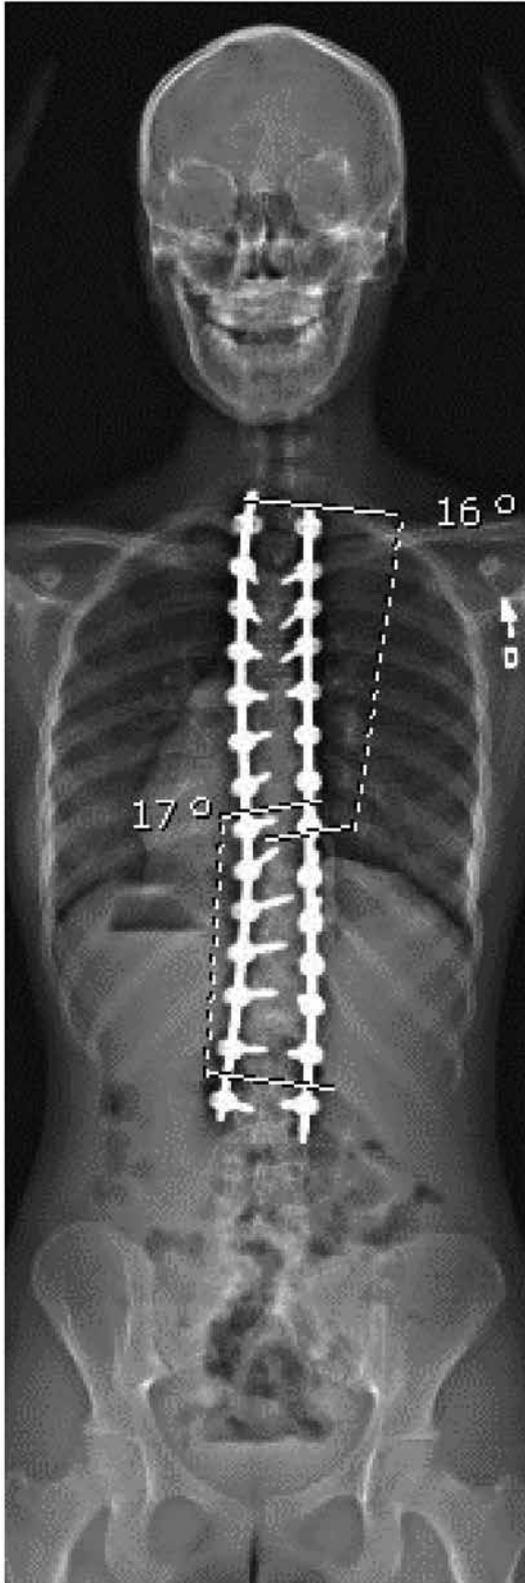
Radiography of the spine in the longitudinal plane in a standing position after corrective spinal surgery for scoliosis.
